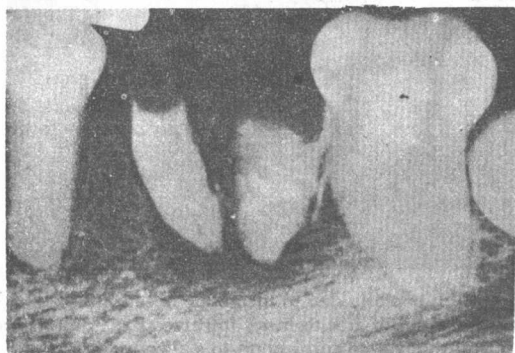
Dentinogenesis imperfecta. Radiographs show the characteristic bulbous crowns, short roots and obliterated pulp chambers.
